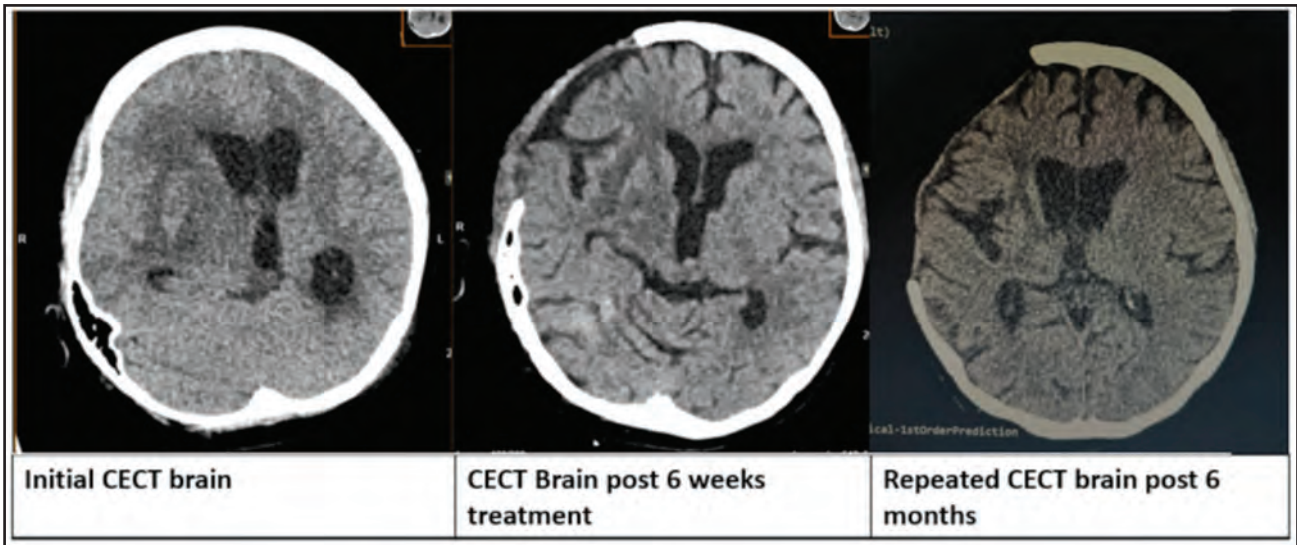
Serial Contrasted Enhanced CT Brain.
